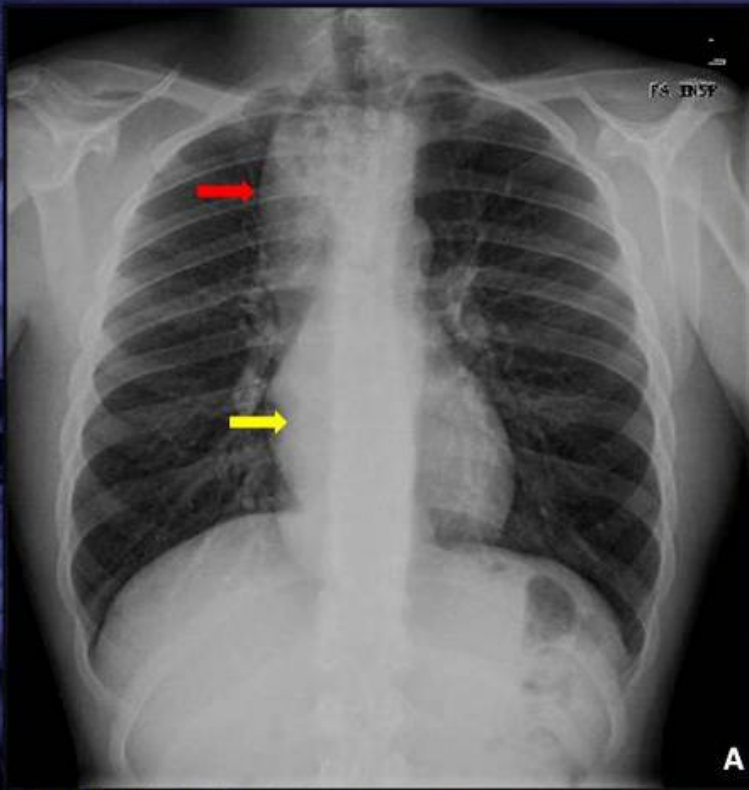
(A) Frontal chest radiograph of a 18-year-old patient showing widening of the superior mediastinum (red arrow), with some air lucencies patent on the right (debris-filled dilated esophagus). Note also the right convexity of the azygoesophageal recess (yellow arrow), secondary to the opacity of the dilated esophagus behind the right heart border. (B) Frontal esophagogram in the same patient confirmed the diagnosis of achalasia.
